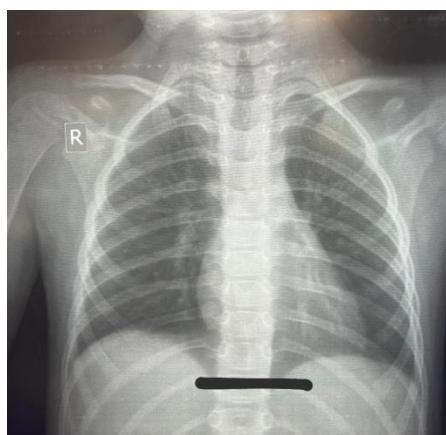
In Patient No. 1, no radiographic evidence of pneumonia was observed on the chest radiograph on day 1 of illness.
